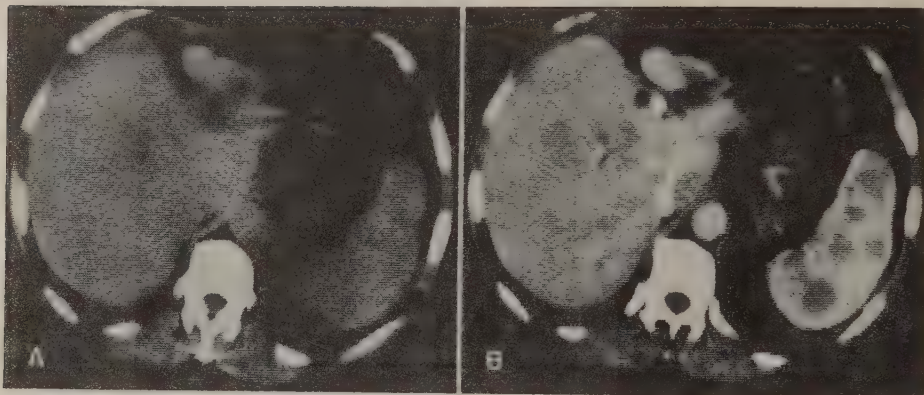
CT examination of patient with multiple carcinoid metastases in liver and spleen. A Nonenhanced examination does not demonstrate metastasis. B Contrast-enhanced examination show metastasis in liver and spleen.
